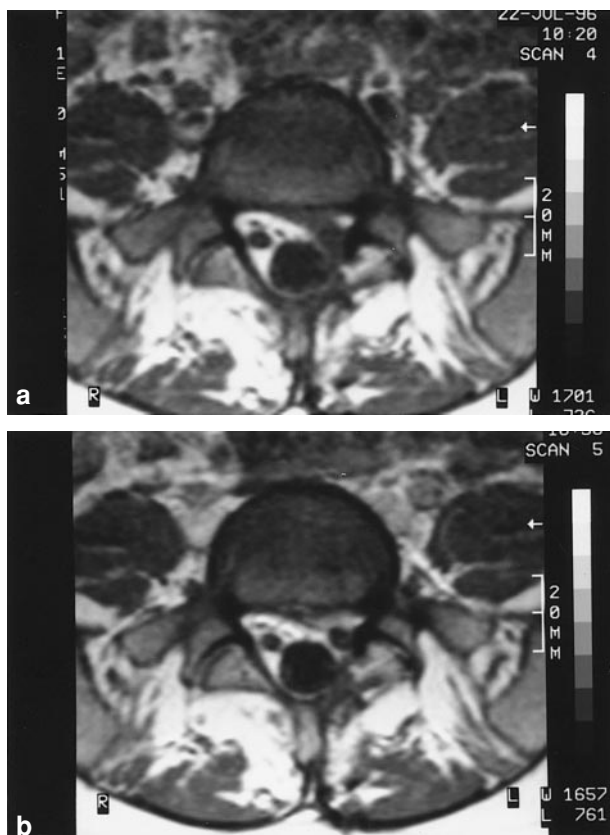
(a) Nonenhanced T1-weighted axial MRI at L5-S1 shows a mass anteriorly and to the left in the spinal canal, which blurs the contours of the left S1 nerve root. The right nerve root is surrounded by bright fat tissue. (b) Post contrast scan reveals homogenous enhancing tissue consistent with scar tissue and thickening of the left nerve root
